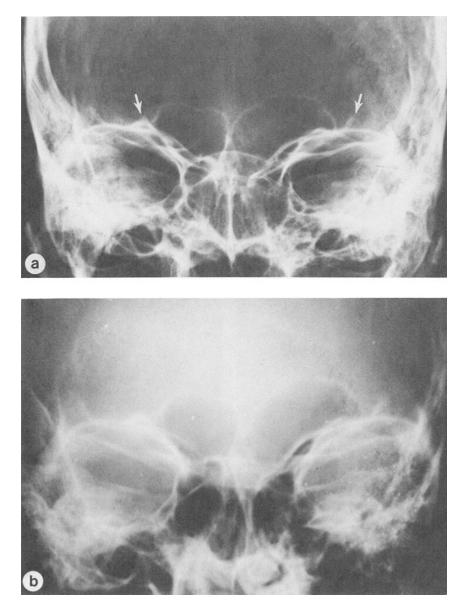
Case 7: (a) Postmortem radiograph of carefully positioned skull shows small, smoothly curved frontal sinuses with tiny lateral air cells (arrows). (b) Comparison with premortem clinical radiograph demonstrates identical features.
